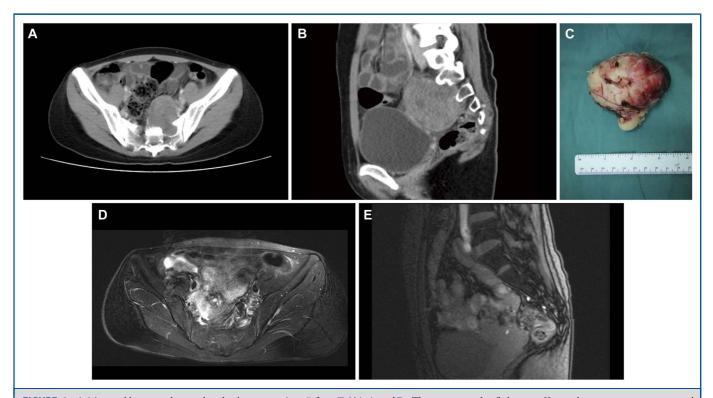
A 24-year-old woman diagnosed with schwannoma (case 7 from Table). A and B, The tumor was classified as type II according to preoperative computed tomography. C, Gross view of the tumor after en bloc resection. D and E, No local recurrence was observed during an 18.3-month follow-up.
